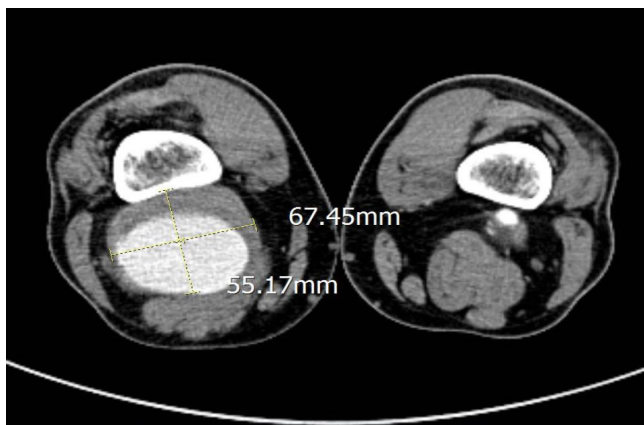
CT image of the mass
